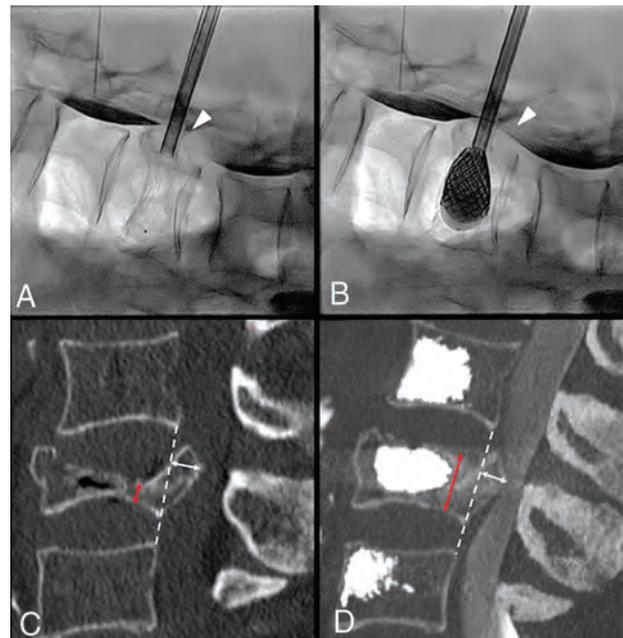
Severe L3 vertebral body collapse (A) in a 74-year-old woman with osteopenia following minor trauma. Intraoperative myelogram through intradural injection of contrast agent at L1–L2 (arrow, A) shows an opacification defect of the dural sac dorsal to the retro-pulsed fragment at L3 (arrowhead, A). On fracture reduction through balloon-expanded vertebral body stents (B), the myelogram shows greater opacification of the dural sac at L3 (arrowhead, B), a real-time indirect sign of ligamentotaxis and partial central canal clearance. C and D, Preoperative and postoperative midsagittal CT images used for measurement of vertebral body height at the maximum point of collapse (red arrows) and of posterior wall retropulsion (white arrows) perpendicular to the dashed white line connecting the postero-inferior corner of the cranial vertebral body and the postero-superior corner of the caudal one, representing the expected original posterior wall, now intersecting the PWR.
